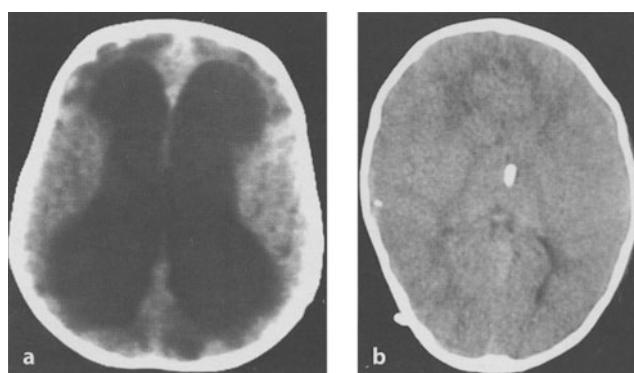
a CT scan of a 1-month-old child presenting with hydrocephalus due to intraventricular hemorrhage. Note the significant periventricular edema. b CT scan of the same child 1 year after CSF shunting (performed shortly after a). There is re-expansion of the cerebral mantle and marked reduction of the ventriculomegaly. Despite normal brain morphology, this child presents a mild to moderate degree of developmental delay and minor motor sequelae
